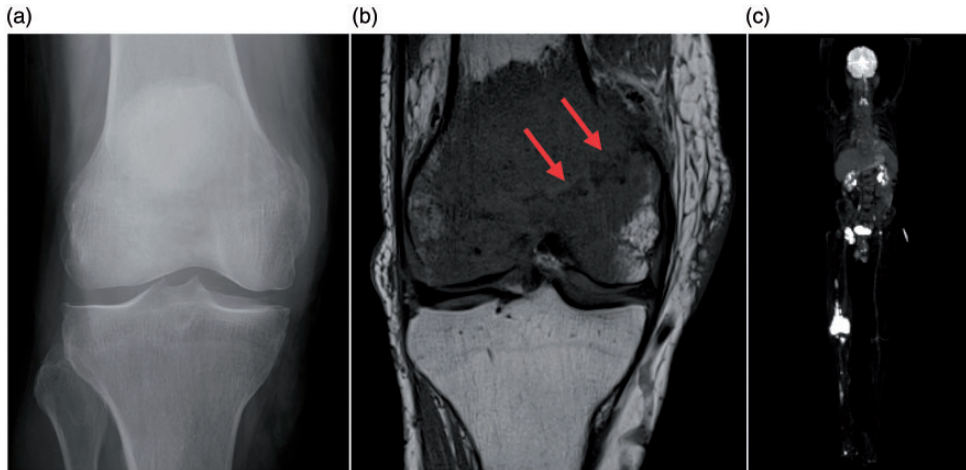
a: Plain film radiographs (anterior posterior view) of the right knee demonstrating no obvious pathology. b: Coronal T1-weighted magnetic resonance imaging of the right knee showing extensive metastasis with cortical infiltration and a fracture line of the medial femur condyle (arrows). c: Whole-body positron emission tomography scan displaying dissemination to multiple sites: bilateral inguinal lymph nodes, right femur, right fibula, right tibia, and right fourth metatarsal bone.
